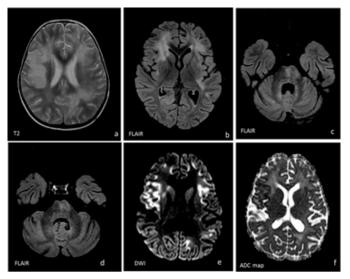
(a) Areas of hyperintensity on T2-WI and FLAIR in the cerebral hemispheres, involving mostly the white matter but also the cortex, extending to the left anterior striatum and right lenticular nucleus (b). (c, d) In the posterior fossa, areas of T2 and FLAIR hyperintensity are seen in pons, middle cerebellar peduncles, dentate nucleus, and deep white matter of both cerebellar hemispheres. (e, f) Most of the affected cortex show restricted diffusion.
